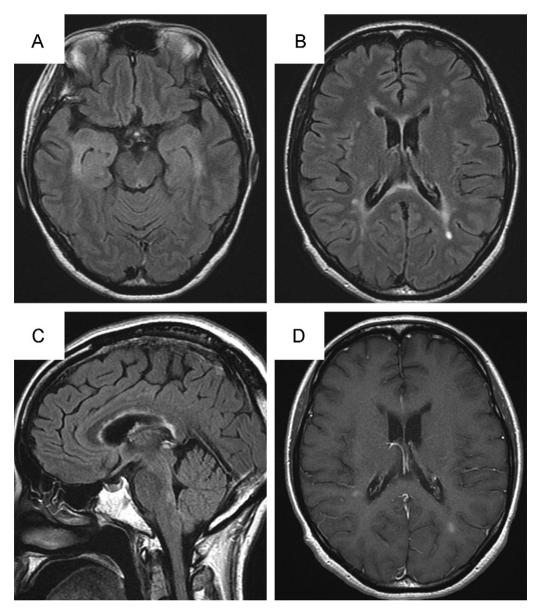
Brain MRI performed on admission showing a high-intensity lesion on FLAIR images of the bilateral medial temporal lobes (A); some MS plaques (ovoid lesions) are noted around the lateral ventricle (B and C); an image obtained with gadolinium enhancement (D) is also shown.
